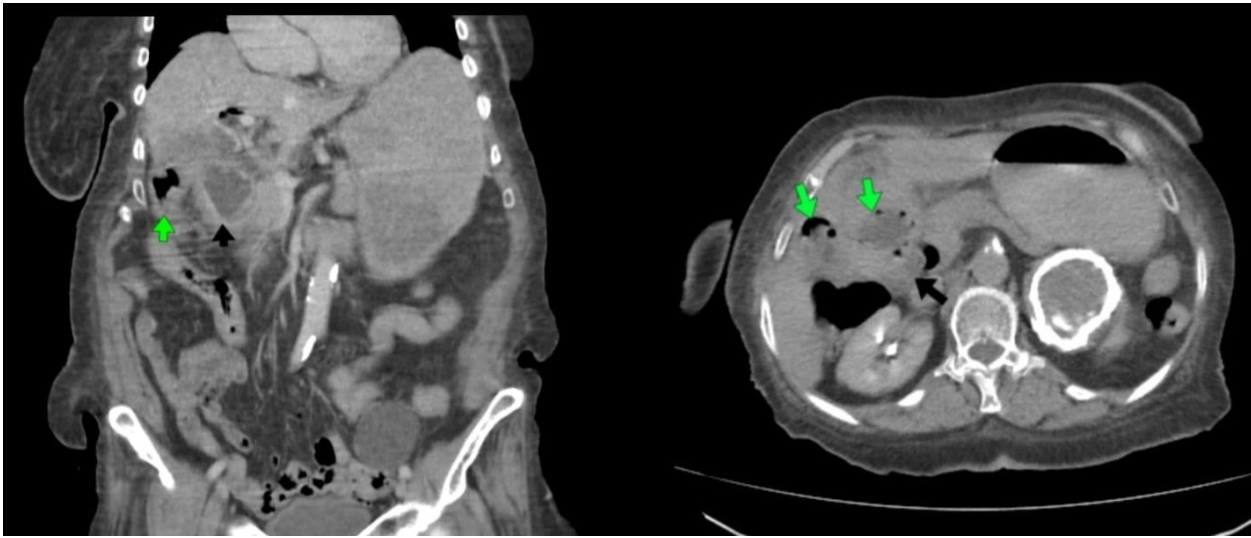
Multislice CT of the abdomen with oral and IV contrast showing partially distended irregular gall bladder containing multiple gas vacuoles (green arrows) which are seen compressing the second part of the duodenum (black arrows) with a fistulous track in between exerting proximal dilation of the stomach. Obvious pneumobilia is also seen.
